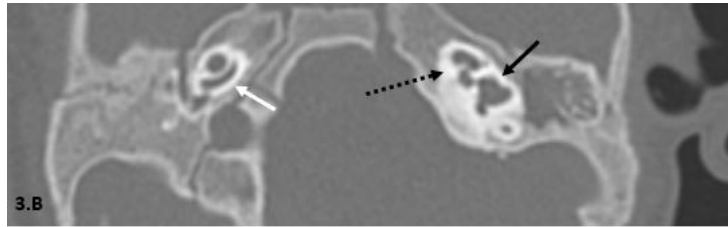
B: Axial CT view, bone window revealed left side cystic vestibule (black solid arrow), right cochlea shows 1.5 turns only instead of 2.5 turns (white arrow), left side dilated cystic apex of the cochlea (dashed black arrow).
